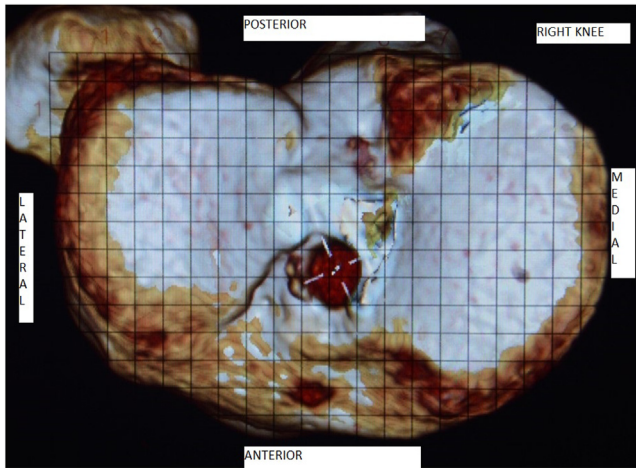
Postoperative 3-dimensional computed tomography of proximal tibia for evaluation of tibia tunnel position with the superimposed grid of Bernard et al.¹⁵ so as to quantify tunnel position.
